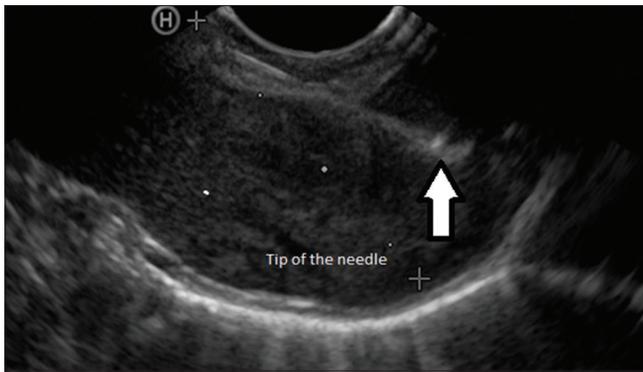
Linear endoscopic ultrasound image with scope in cervical esophagus showing transesophageal needle biopsy
